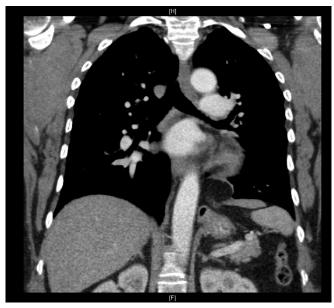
CT Scan, Frontal View. Left-sided diaphragmatic defect with herniation of gastric fundal diverticulum.
